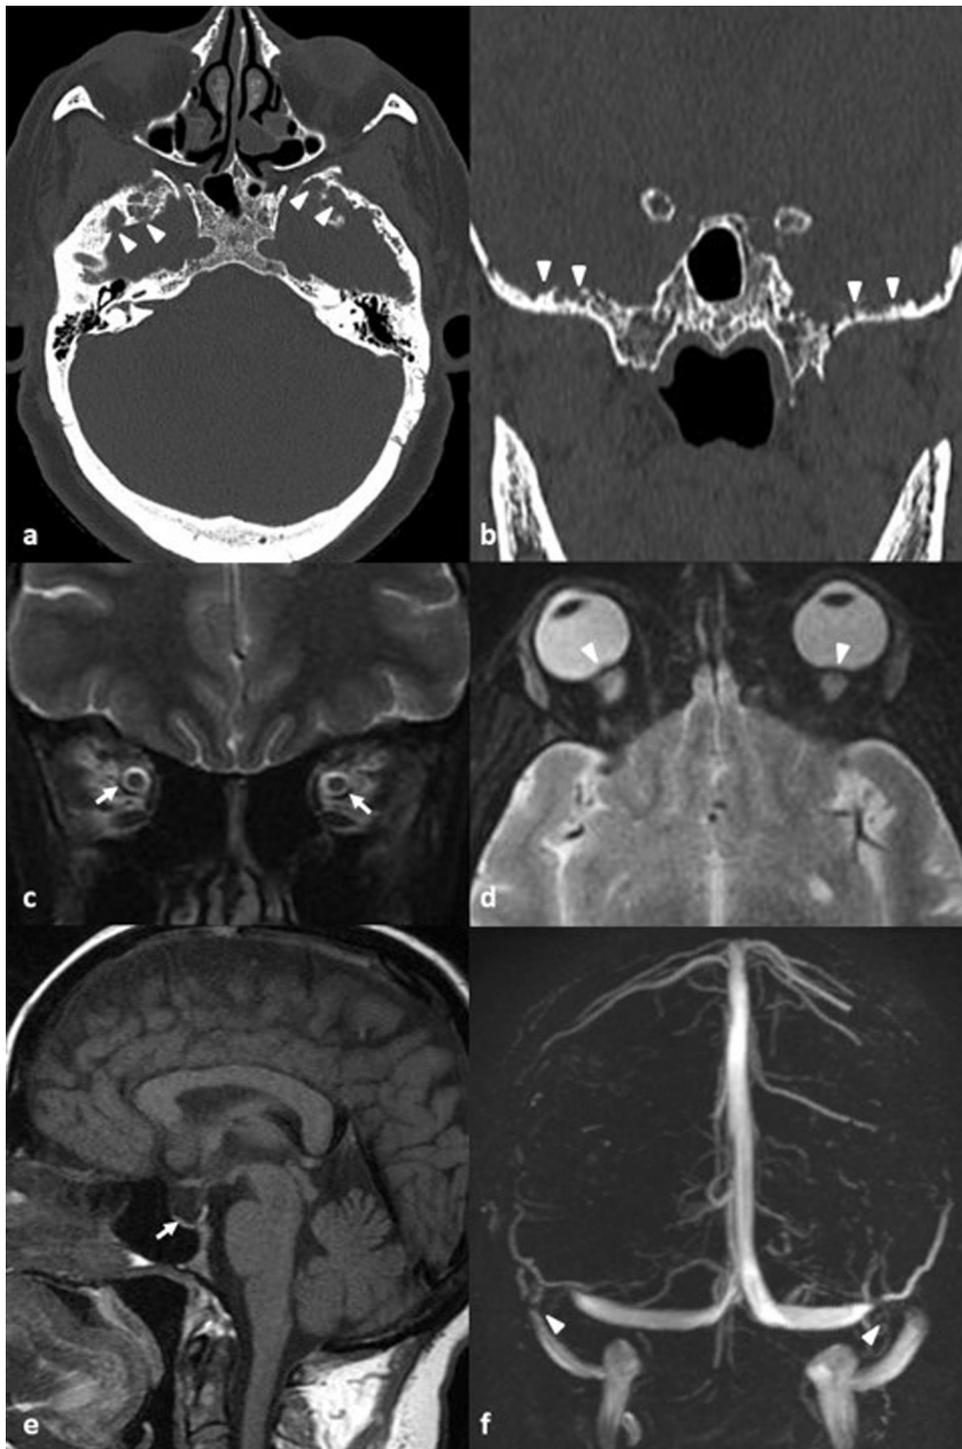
Thirty-six-year-old woman with intermittent headache and visual disturbance: a–b: axial and coronal CT images in bone window showing bony scalloping in floor of middle cranial fossa (arrowheads); c–d: coronal and axial T2-weighted fat saturated images of orbit showing prominence of perioptic CSF spaces (arrows) and mild protrusion of optic nerve head into the posterior chamber (arrowhead); e–f: sagittal T1-weighted and MR venography images showing empty sella (arrow) and bilateral transverse sinus stenosis (arrowhead) consistent with Idiopathic intracranial hypertension.
